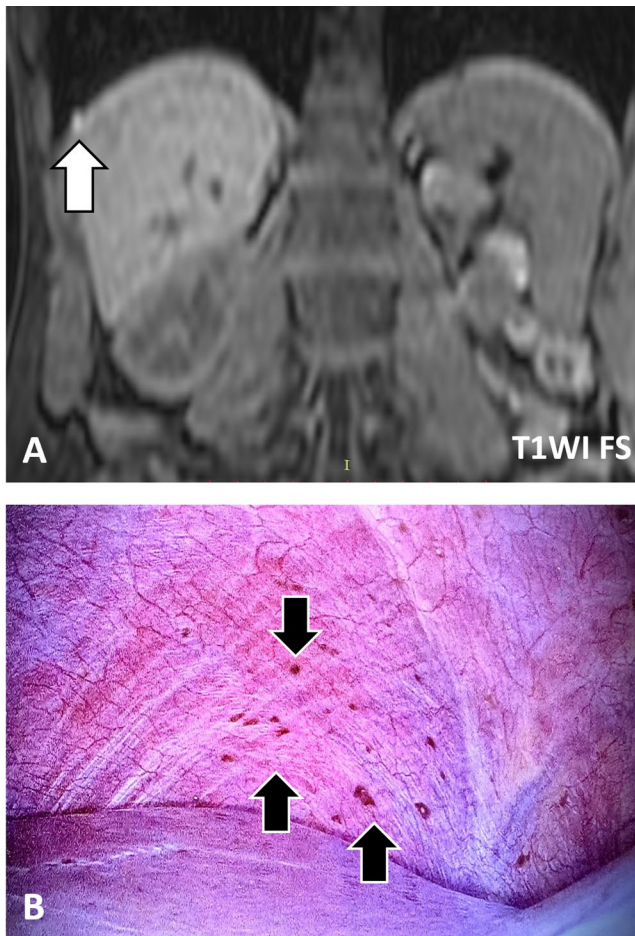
18-year-old woman with right upper quadrant pain. A MRI: axial T1WI FS image demonstrates a single right subdiaphragmatic endometriotic implant. B Laparoscopy reveals multiple reddish and bluish subphrenic lesions (black arrows) corresponding to hemorrhagic endometriotic implants at different stages of evolution
